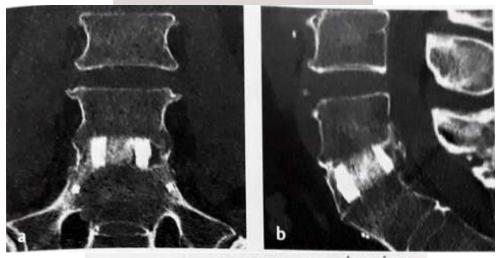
(a, b) CT image showing solid union with continuous trabecular bone formed inside the metallic cage and around it.
